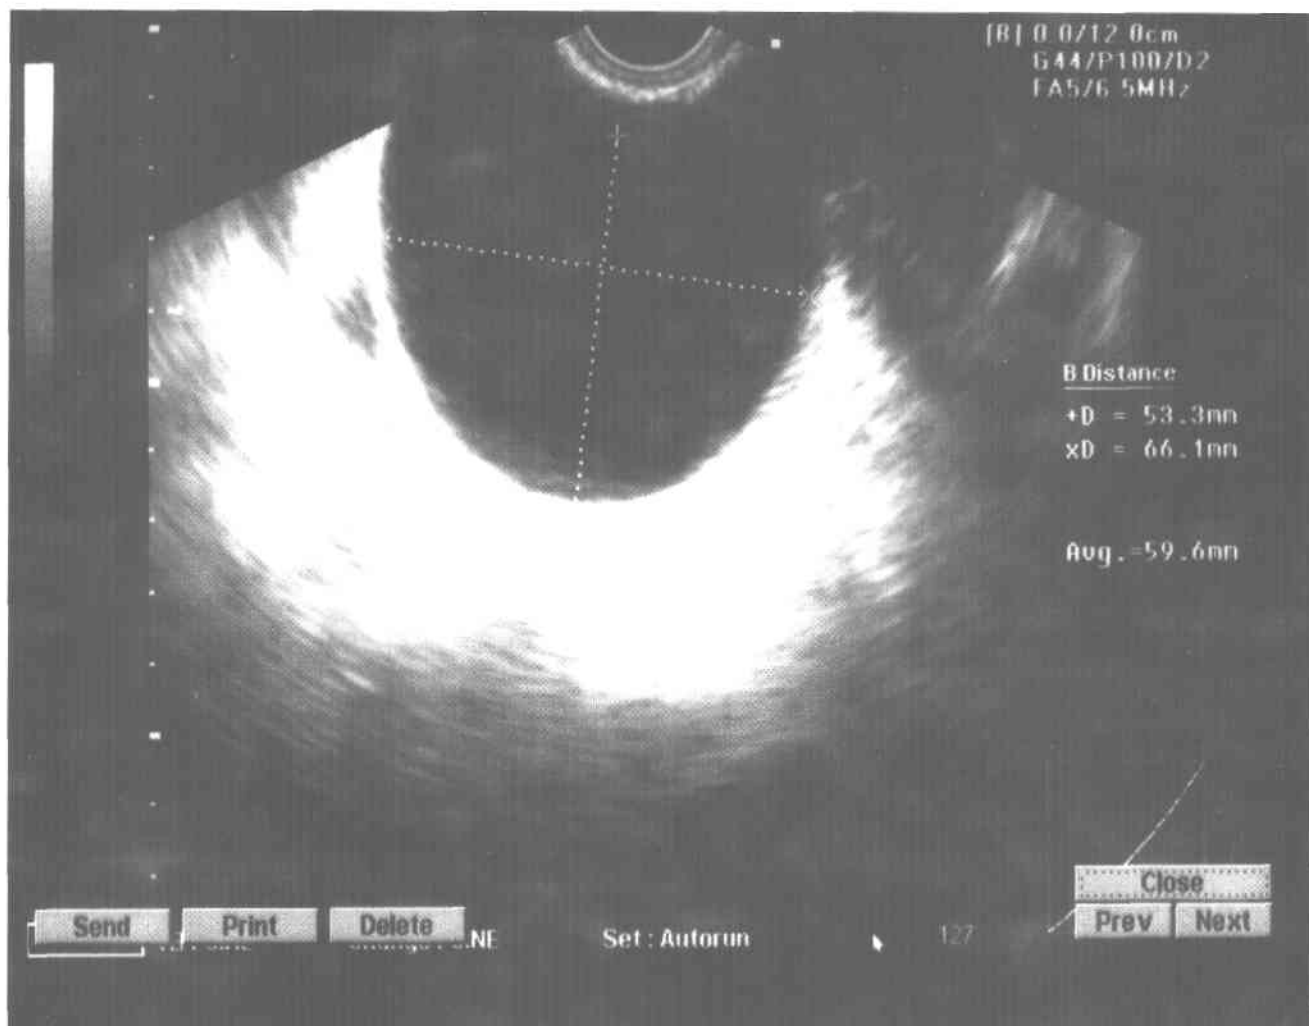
Transvaginal ultrasound appearance of a functional ovarian cyst.
